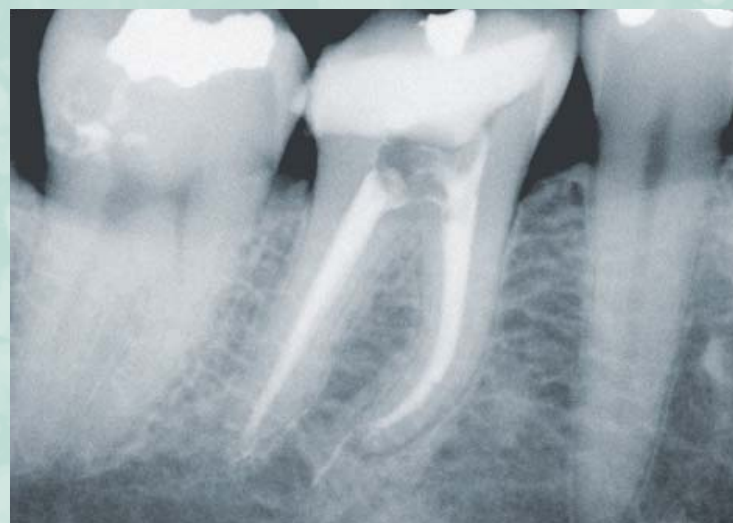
Radiograph after completion of endodontic therapy. Nondisplaceable vertical fractures were found buccolingually and mesiodistally.
